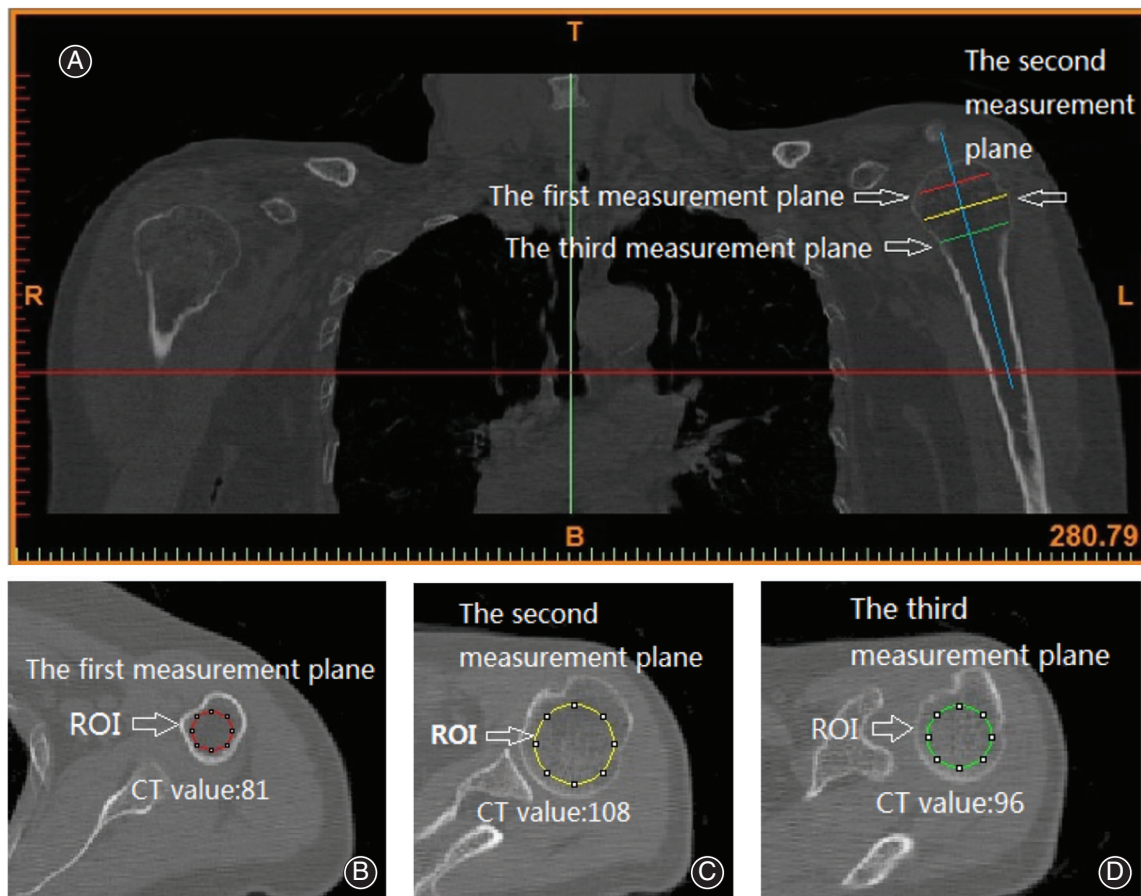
Method of measuring the proximal humerus average CT value (CT_{Mean}). (A) In a horizontal CT image, the center of the humerus medullary cavity was determined first. Then, the proximal humerus was divided equally into three measuring planes along the humerus medullary cavity. The ROI was placed in the proximal humerus and the CT value of the bony structure inside ROI was obtained by ImageJ software; (B) CT value inside the ROI in the first measuring plane; (C) CT value inside the ROI in the second measuring plane; (D) CT value inside the ROI in the third measuring plane. CT, computer tomography; ROI, region of interest.
